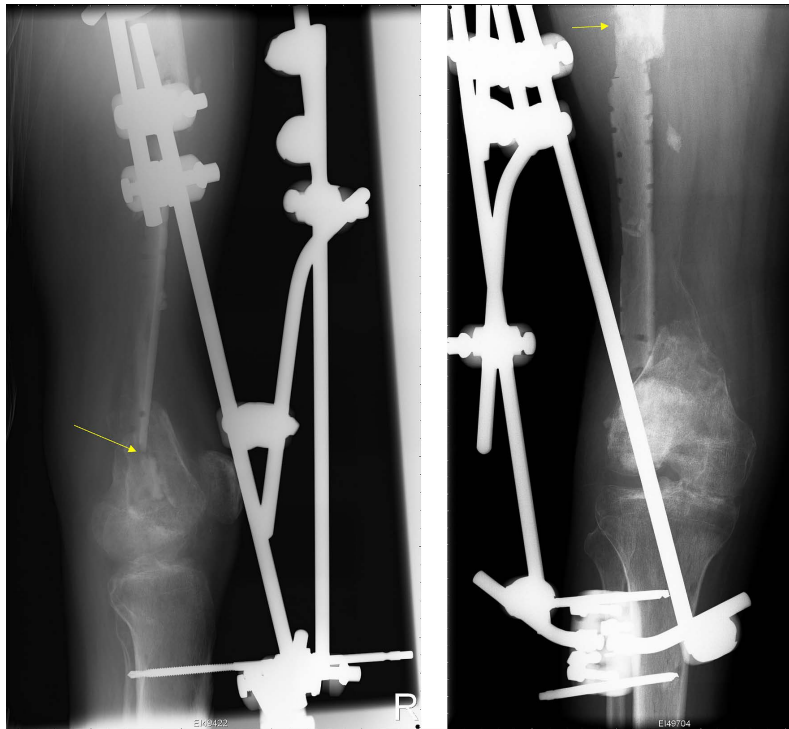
Case no. 4. Radiographs after removing the intramedullary nail. The infected femur sequester was also removed.
